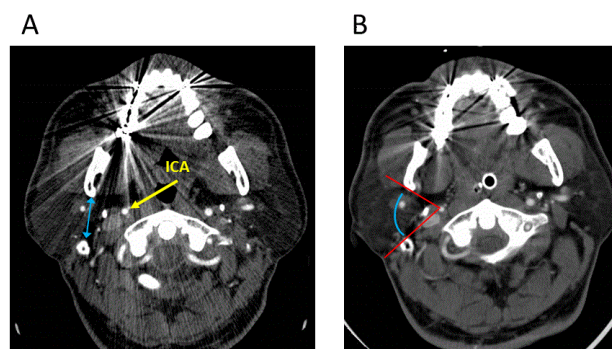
Measurements on axial computed tomography angiography images at the level of the tip of the mastoid process. (A) Mastoid-mandible distance between the anterior margin of the mastoid process and posterior margin of the mandible. ICA, internal carotid artery. (B) Mastoid-ICA-mandible (MIM) angle between the line connecting the anterior margin of the mastoid process and the center of the ICA, and the line connecting the posterior margin of the mandible and the center of the ICA.
